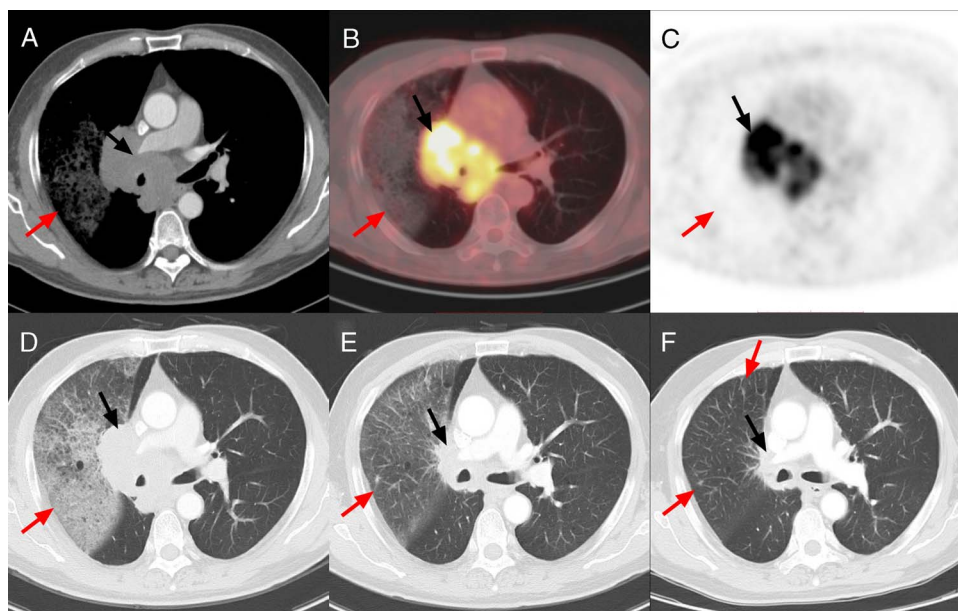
A 67-year-old man with small cell lung cancer of the right hilum. Axial contrast-enhanced CT (A), PET/CT (B), PET (C), and thin-slice chest CT (D) showed an FDG hypermetabolic mass ($SUV_{max} = 11.2$) in the right hilum (black arrow) with occlusion of the right pulmonary artery. A large pulmonary infarction was observed in the upper lobe of the right lung with no obvious FDG metabolism (red arrow). After 40 and 80 days of antitumor treatment, axial thin-slice chest CT (E and F) showed the mass in the right hilum was significantly reduced, and the right pulmonary artery was patent (black arrow). Pulmonary infarction diminished in size over time, leaving a residual fibrous scar (red arrow).
